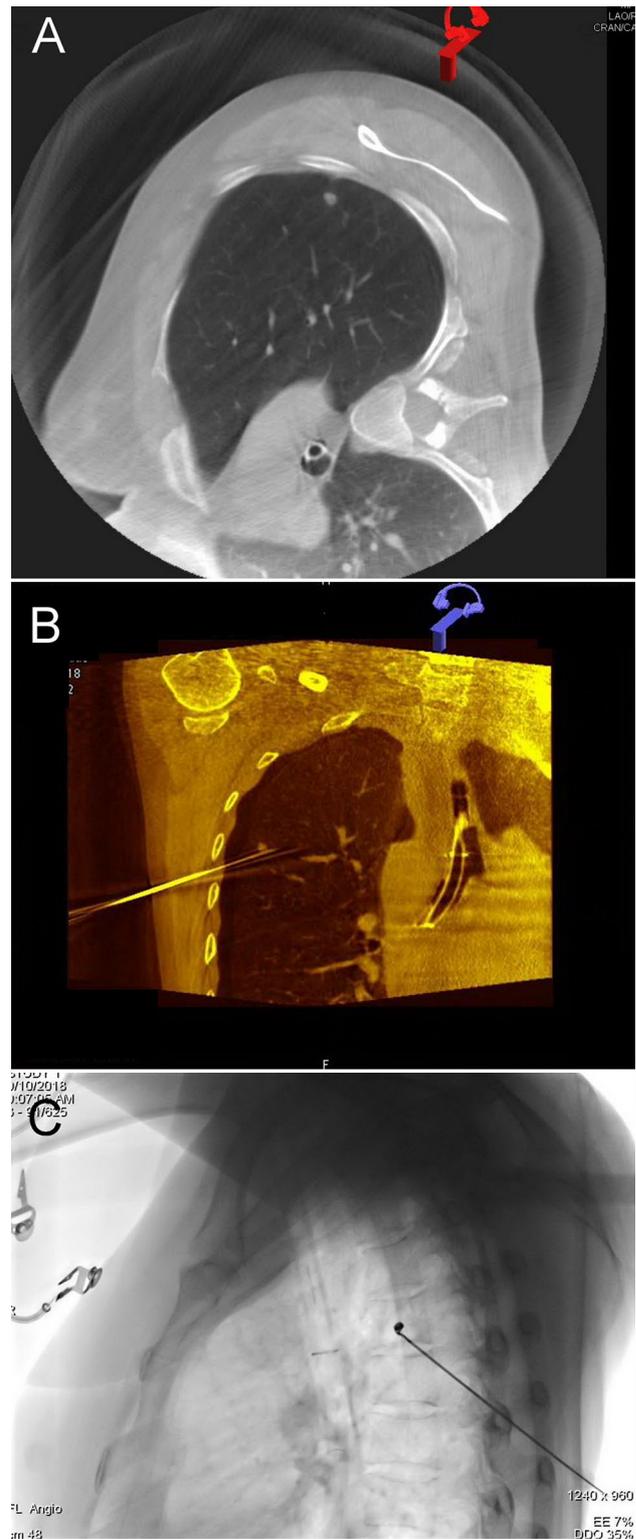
A Cone-beam CT image of a lung nodule obtained with the patient placed in the lateral decubitus position. B Cone-beam CT image obtained after needle puncture. C Placement of the microcoil under fluoroscopy using the coaxial needle technique
